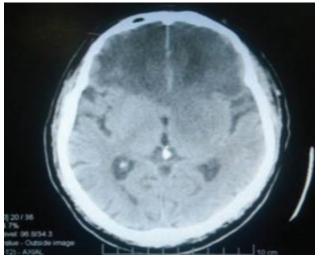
CT scan of the brain showing bilateral frontal lobe infarct*
